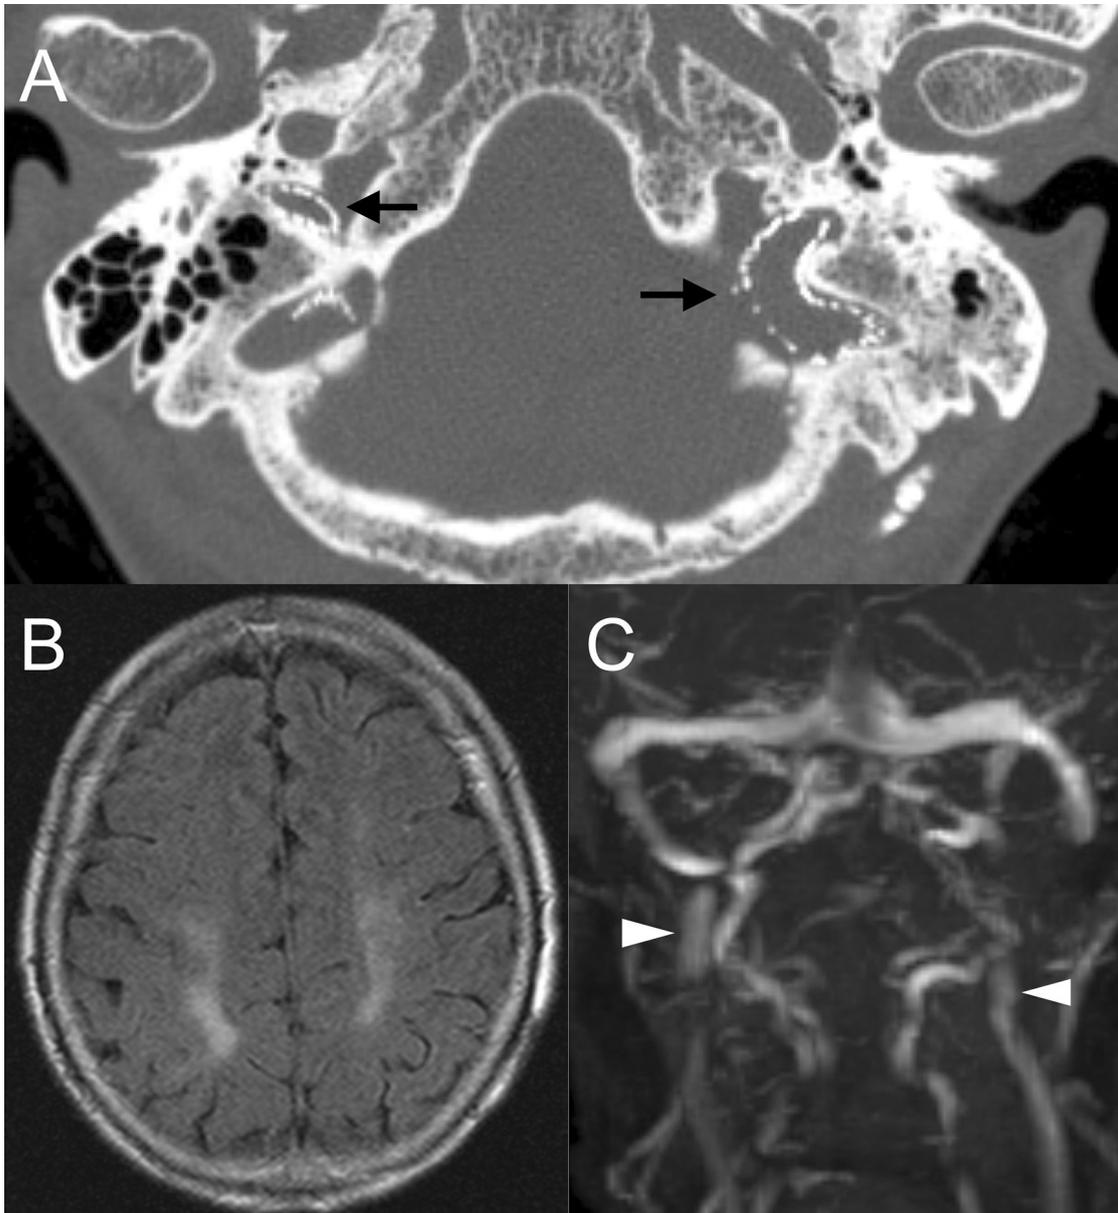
(A) Post-stenting CT scan demonstrating that the stents in the both jugular bulb are sufficiently expanded (arrow). (B) MR image (FLAIR) after 1 month from stent placement showing disappearance of cortical edema. (C) Time-of-flight MR venography (frontal projection) after 1 month from stenting disclosing good patency of the both internal jugular veins (white arrowheads).
